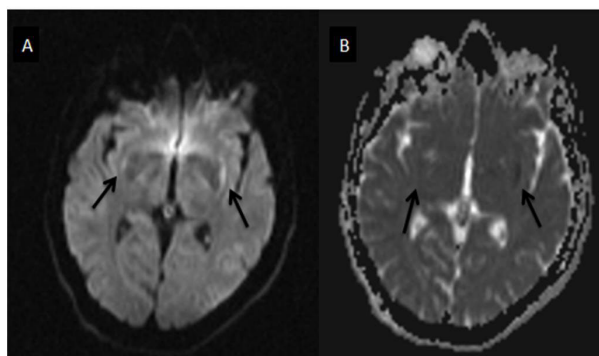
Diffusion weighted images (DWI) shows (a) hyperintensity on DWI images and (b) hypointense appearance on ADC images in both lateral putaminal areas due to restricted diffusion (arrows).
